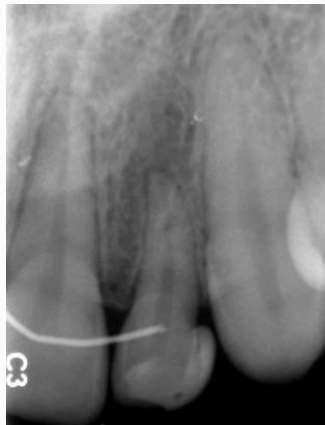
Pre-operative radiograph: Radiograph of maxillary right lateral incisor showing short clinical root.
